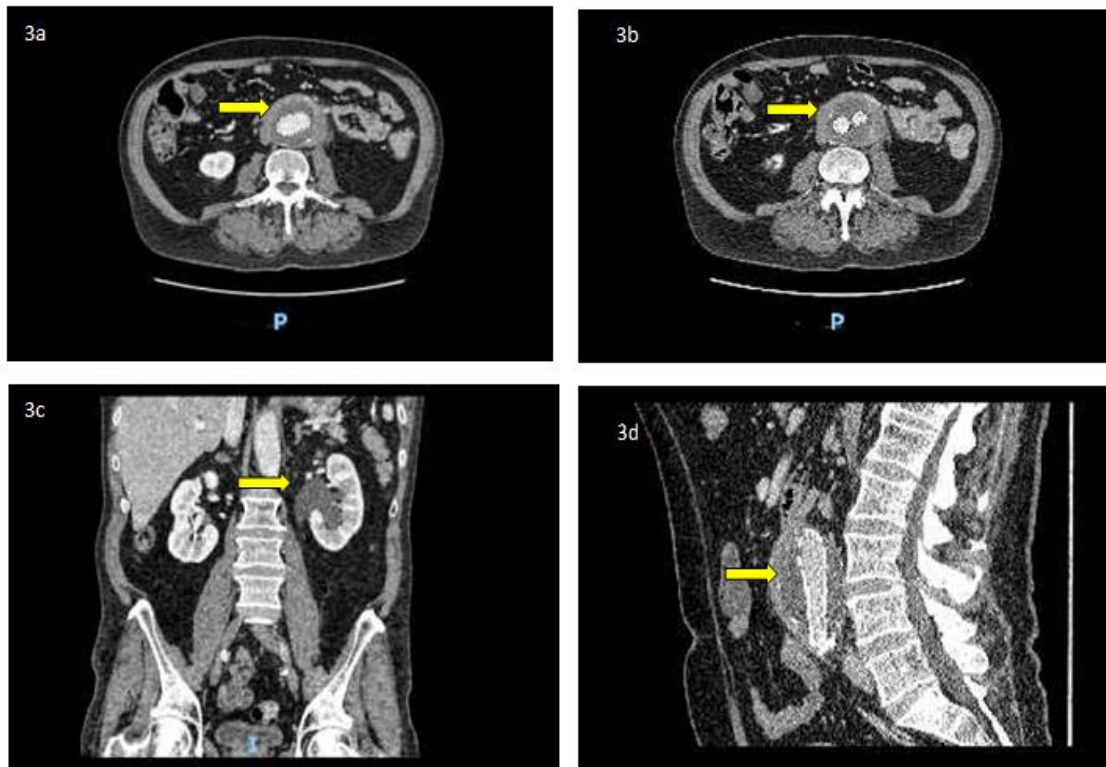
Contrast enhanced CT CAP axial view showing evidence of inflammation and mural thickening around the endovascular stent repair. Fig. 3c. Contrast enhanced CT CAP coronal view indicating hydronephrotic left kidney. Fig. 3d. Contrast enhanced CT CAP sagittal view
